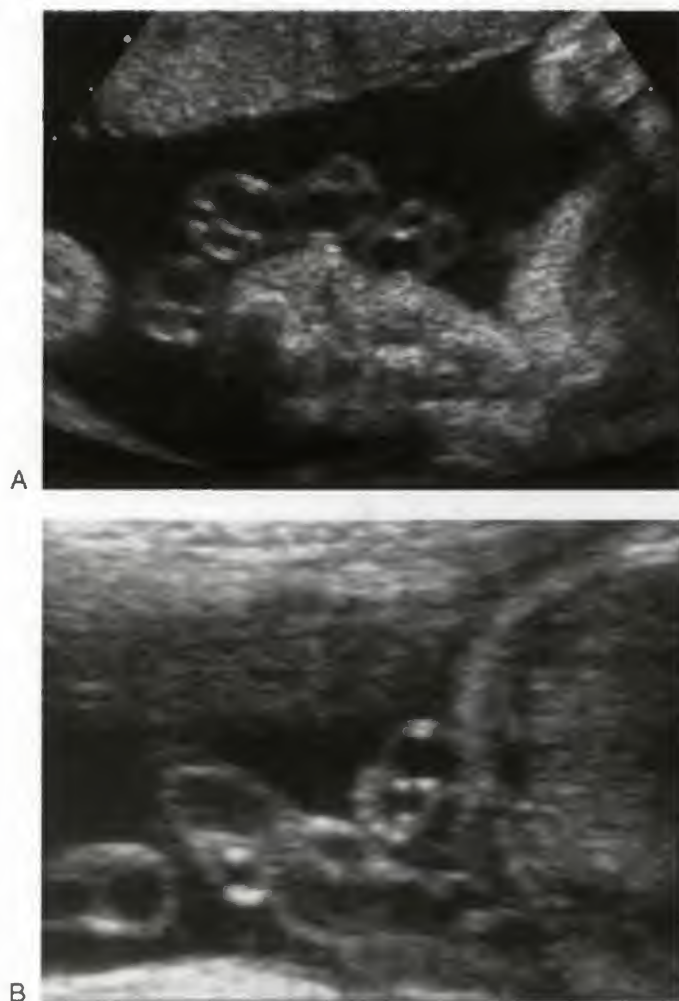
A. Transverse view showing a normal three-vessel umbilical cord (two arteries and one vein). B. An example of a single umbilical artery (arrow) with a two-vessel cord seen on this ultrasound image.
